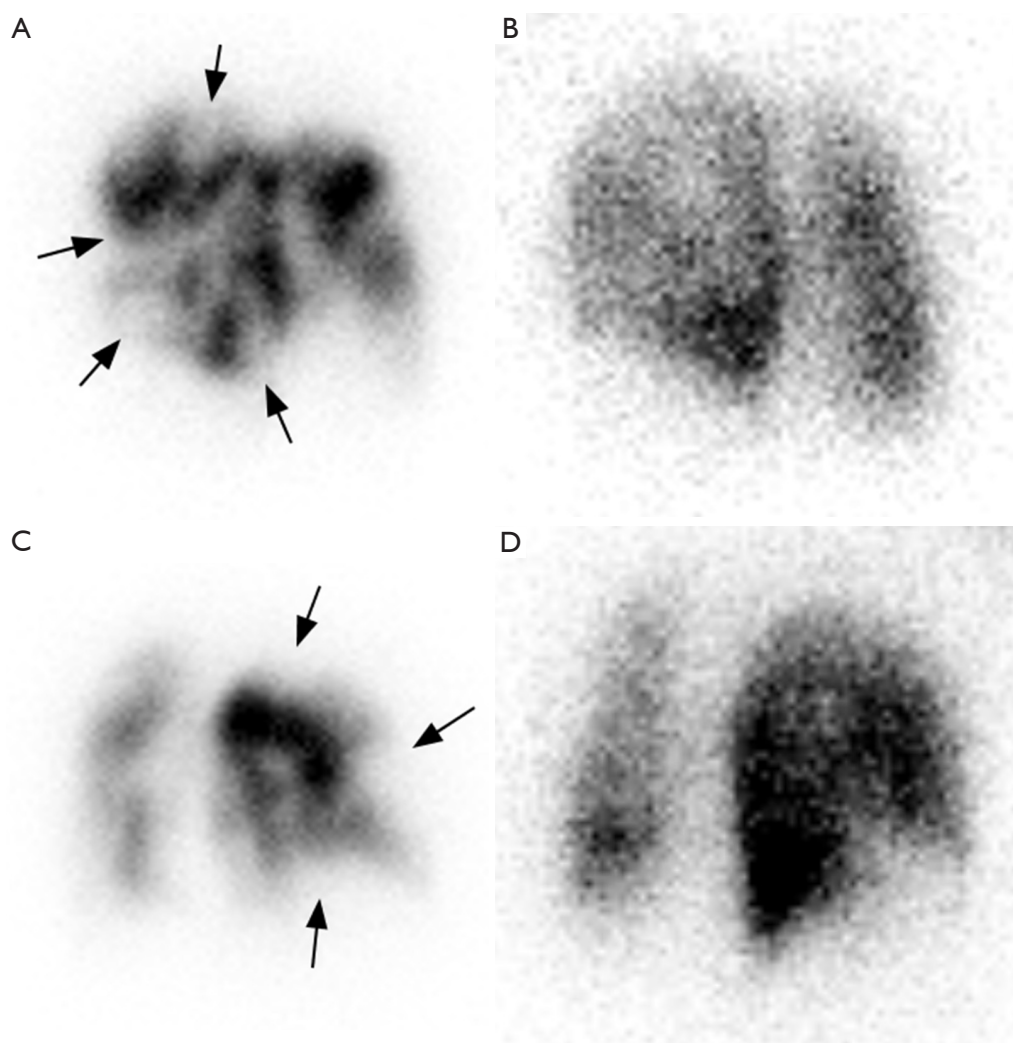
Left posterior oblique (LPO) imaging with intravenous injection of albumin macroaggregate-^{99m}Tc revealing multiple segmental perfusion defects in the left lung (arrows, A), with corresponding normal ventilation on LPO imaging obtained with inhalation of ¹³³Xenon (B). Right posterior oblique (RPO) perfusion scintigraphy also revealing mismatched segmental perfusion defects in the right lung (arrows, C) with normal ventilation (D).
